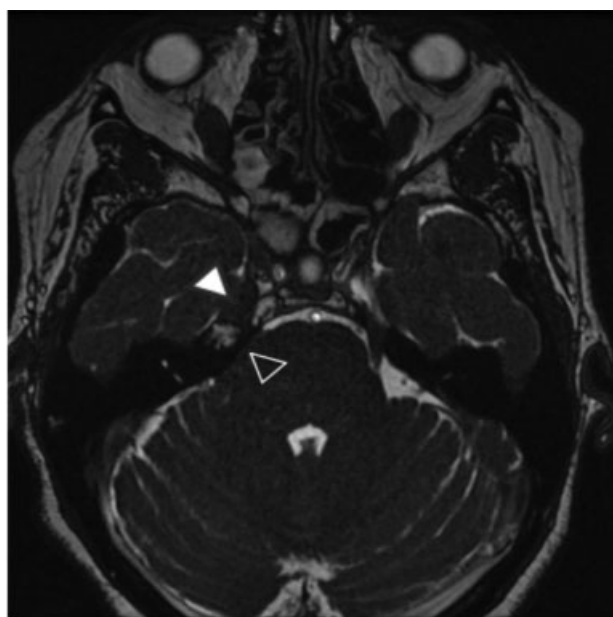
Postoperative T2-weighted magnetic resonance imaging showing partial filling of the cyst by hypointense material (white arrow) extending through the cisternal segment of the trigeminal nerve (black arrow).
